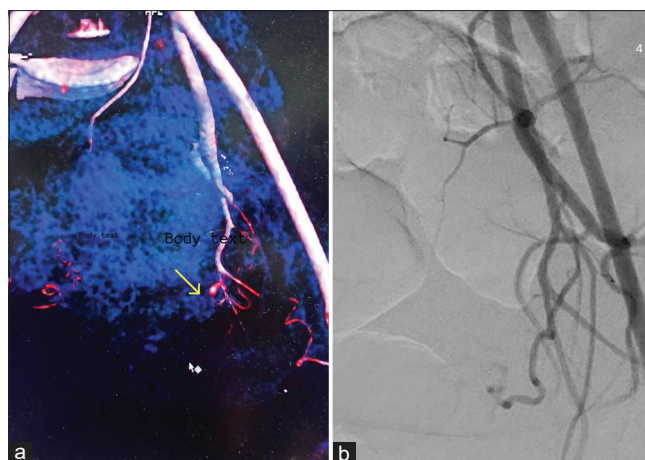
(a) Yellow arrowhead showing uterine artery with pseudoaneurysm in 3D image of computerized tomography (CT) angiography, (b) CT angiography showing aneurysm of left uterine artery
